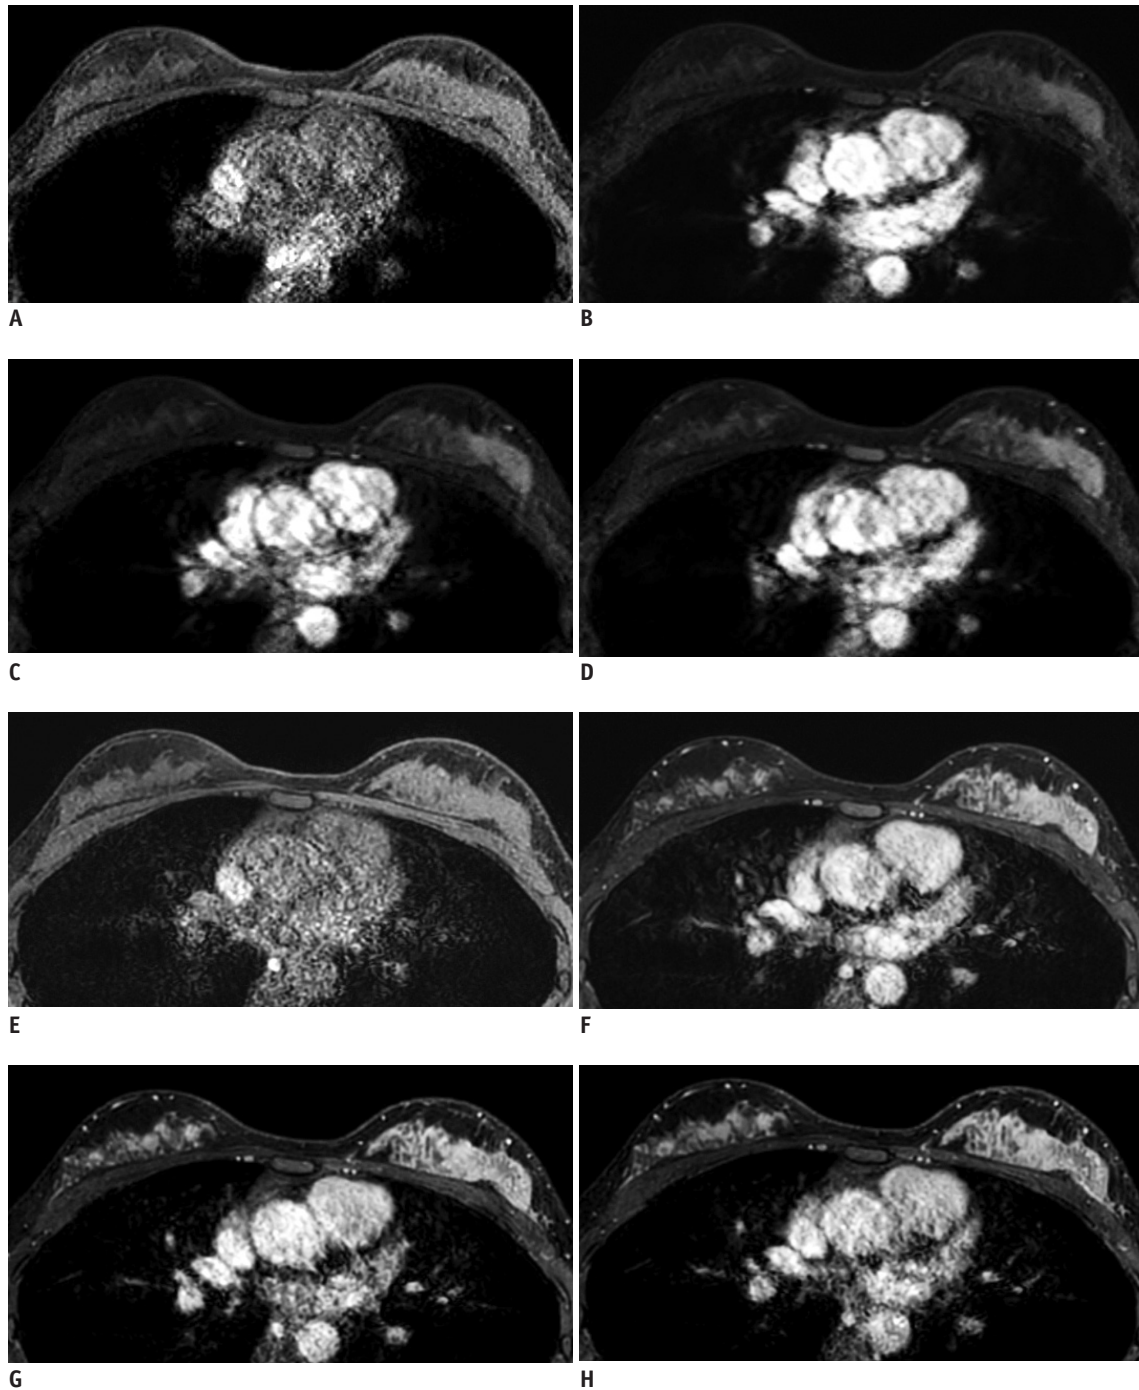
Representative example of four time points of ultrafast (A-D) and conventional (E-H) DCE-MRI. This case was scanned using Skyra (Siemens Healthineers). A. Pre-contrast image. B. U1, time point when tumor begins to become enhanced, 7th phase in this case. C. U2, subsequent time point when tumor begins to become enhanced, 8th phase in this case. D. U3, middle time point after contrast injection, 12th phase in this case. Pre-contrast (E), first (F), third (G), and fifth (H) post-contrast phases of conventional DCE-MRI. Lesion conspicuity scores and size measurements were performed at U2 (B) of ultrafast scans and at first post-contrast phase (F) of conventional scans.
